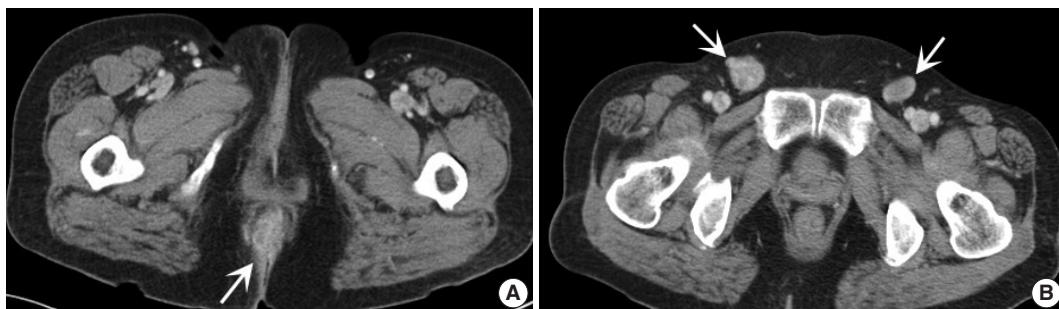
Radiologic findings. (A) Abdominal computed tomography reveals a well-enhancing lesion (arrow) at the right perianal portion. (B) Enlarged bilateral inguinal lymph nodes (arrows) are found.
